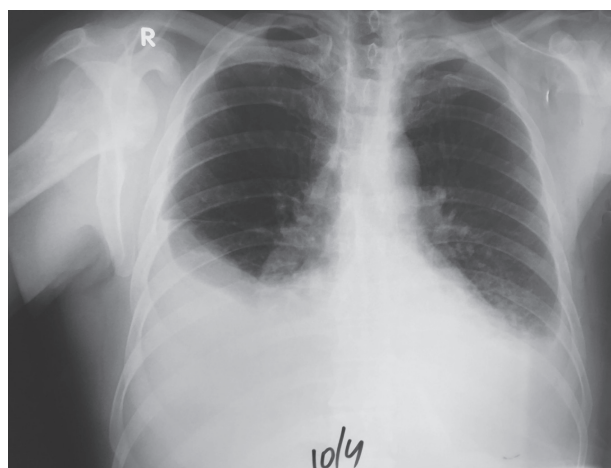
Initial chest X-ray demonstrates bilateral pleural effusion, more prominent at the right side.
